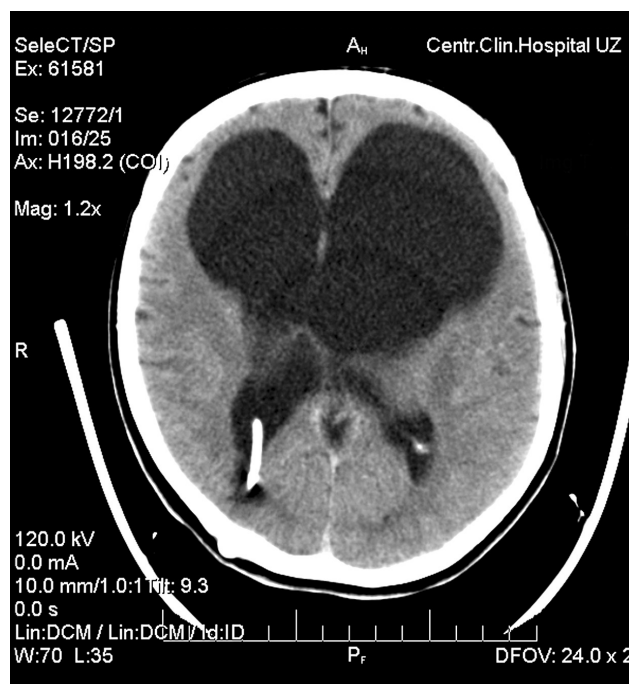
CT patient V. (own observation). Congenital hydrocephalus. Condition after operations with ventricular-atria shunt (VAS), 1995. Enlargement ventricles especially left lateral. White color tube is VAS
